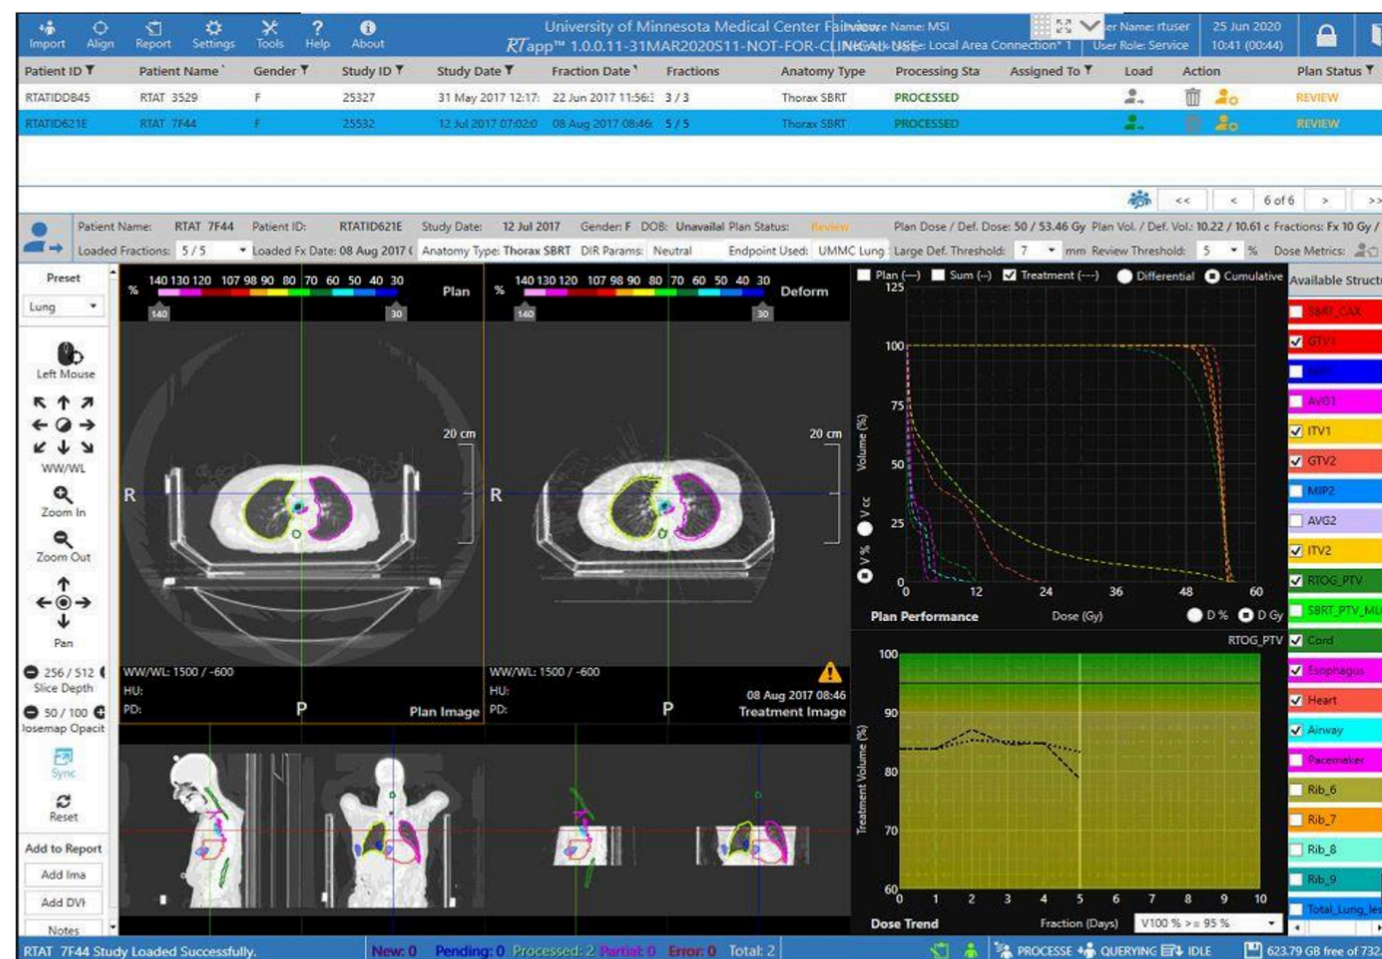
RTapp™ interface allows visualization of planning CT and treatment CBCT simultaneously. The plan performance panel displays DVH of planning dose, individual fraction dose and achieved dose at the end of treatment. The dose trend allows users to observe changes in target coverage or OARs exposure. Users can utilize the available features to examine the updated anatomy and assess the quality of the daily treatment to make clinical decision accordingly.
